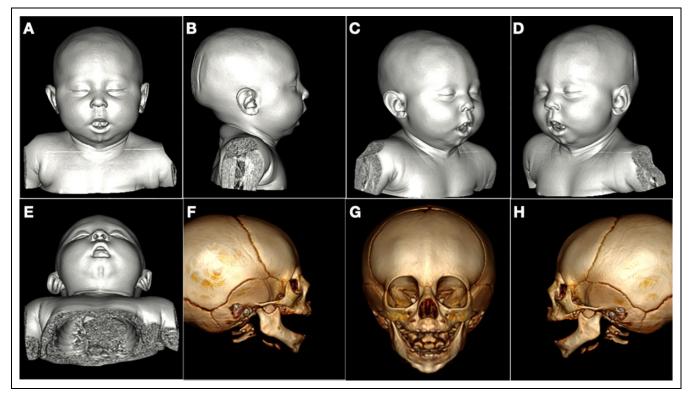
Three-dimensional computed tomographic (CT) images before surgery.
